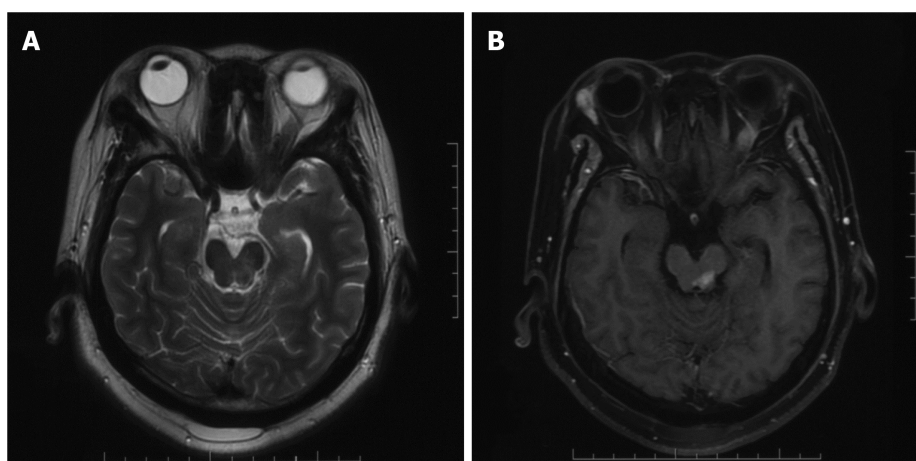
Magnetic resonance imaging reexamination after 20 Gy radiotherapy. A: T2-weighted image showing mixed signal in the left midbrain; B: Contrast-enhanced magnetic resonance imaging showing residual lesion.
